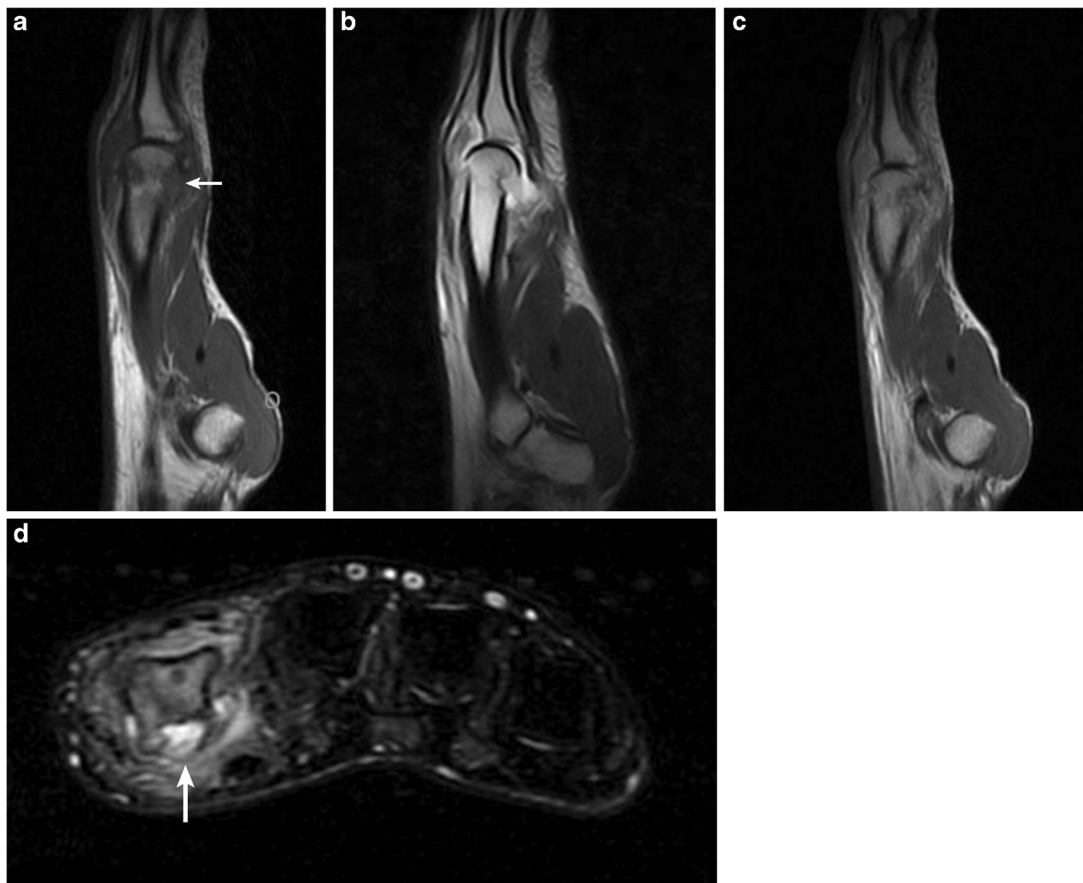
Magnetic resonance images. a Sagittal T1 W (TR/TE = 500/14), b T2 W (TR/TE = 2370/80) and c after contrast medium injection. The lesion is centered on the eroded cortex, and extends minimally inside the medullary cavity, and more extensively into the soft tissues. It has a
